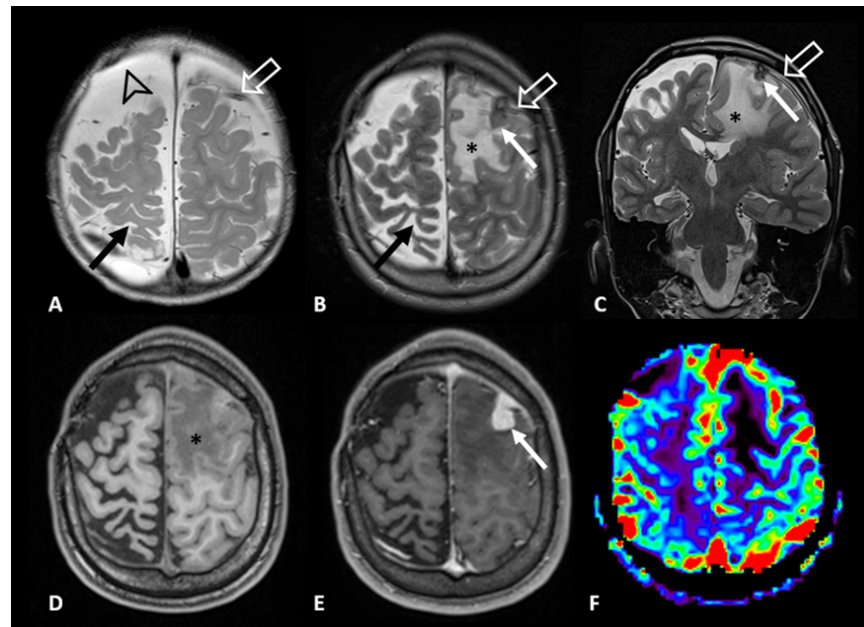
MRI at 16 months (A) and 12 years (B to E) with T2-weighted (B,C) and T1-weighted images before (D) and after (E) gadolinium injection; corrected rCBV perfusion mapping (F); Right frontal subdural hematoma (arrow) and T2 hyperintensity in the right parietal parenchymal lesion progressing to cortical atrophy (black arrows) related to sequelae of the shaken baby syndrome; Left frontal subdural probe (hollow arrows); Appearance of a T2 hypo intense tissue lesion with intense contrast uptake, with no neoangiogenesis in contact with the probe (white arrows); Extensive perilesional edema of the left frontal white matter (asterisk).
